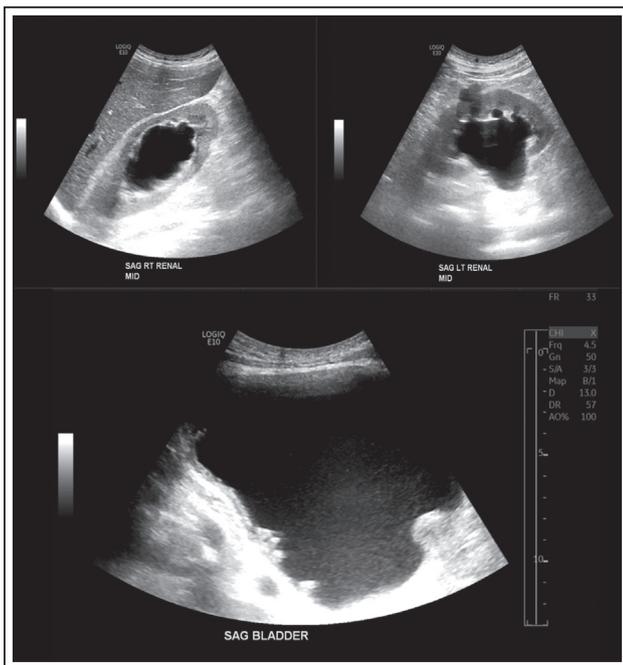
Renal ultrasound – first admission – bilateral hydronephrosis with a large median lobe and full bladder.
